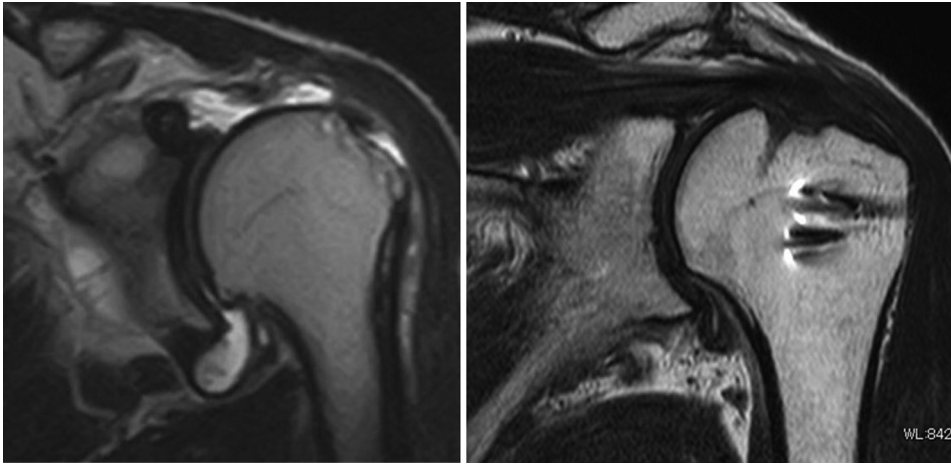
Coronal T2-Weighted Magnetic resonance imaging of the left shoulder before and after the ex-medialization procedure. Left: before surgery; right: after surgery.
